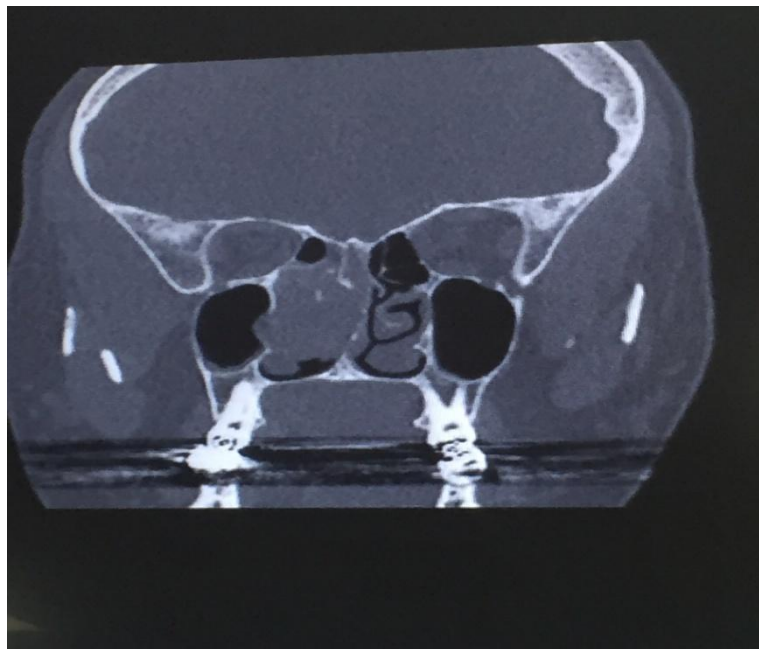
1 CT scan showing mass involving Rt. nasal cavity
